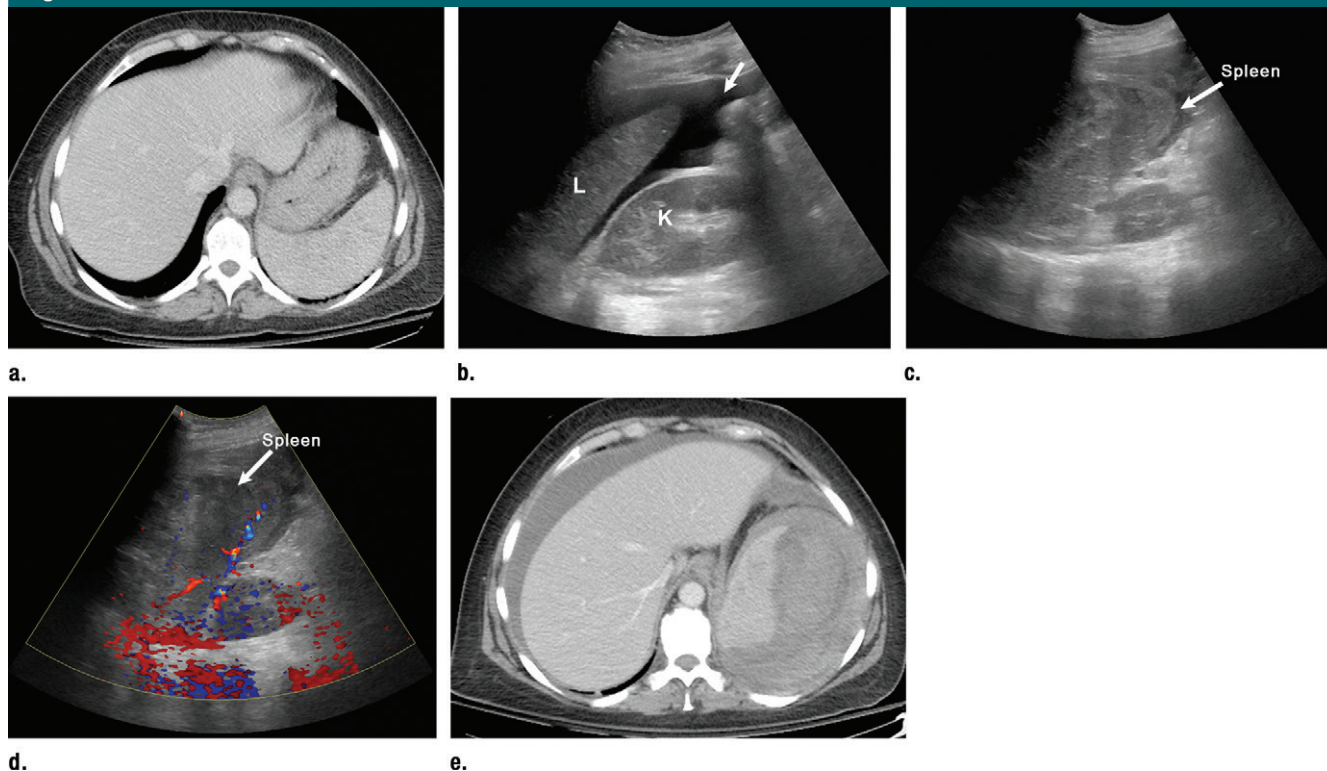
Serial FAST in a 44-year-old man with blunt abdominal trauma from a motor vehicle accident with abdominal pain. (a) Initial CT scan was interpreted as normal. Slight inhomogeneity of the spleen was thought to be due to normal enhancement of splenic pulp. (b) Nine hours later, the patient developed hypotension and a bedside FAST examination was performed, which demonstrated free fluid in the upper abdomen (arrow) and pelvis. L = liver, K = kidney. (c) Real-time images showed marked heterogeneity to the spleen. (d) Color flow demonstrated fairly avascular appearance of the spleen. (e) Patient was resuscitated and underwent CT, during which a large spleen laceration with subcapsular hematoma and free fluid was detected. Patient was rushed to the operating room for successful emergency splenectomy.
